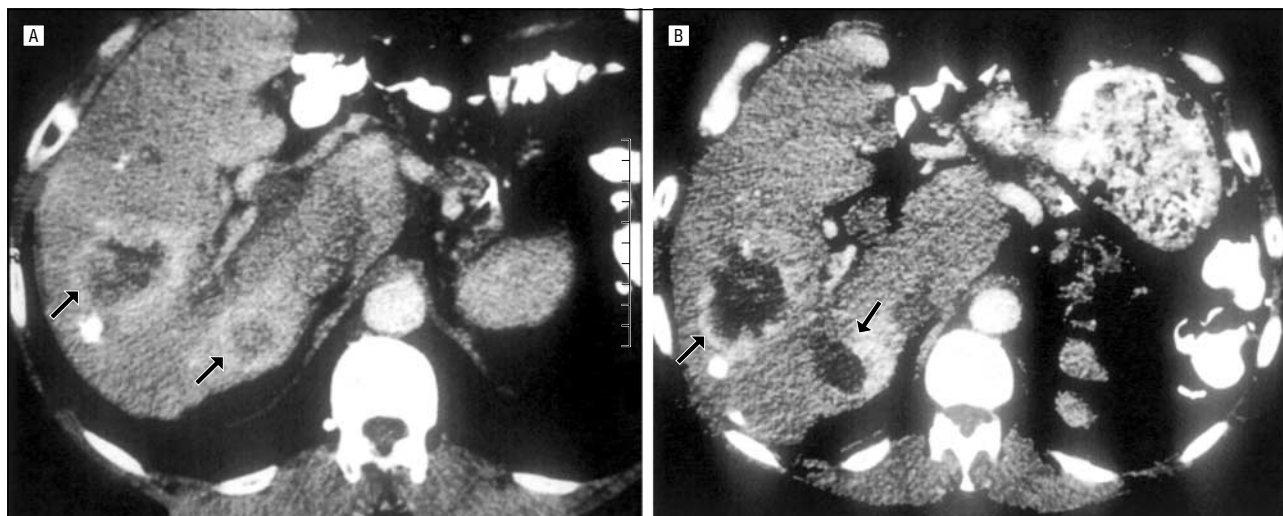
Computed tomographic scan demonstrating persistent tumor following treatment. A, Before treatment for 2 metastatic tumors from a neuroendocrine primary tumor, the uptake of contrast within and surrounding the tumors (arrows) indicates active tumor vascularization. The size of the larger tumor was 7 cm; the smaller, 5 cm. B, Following treatment by percutaneous cryosurgery, the persistence of contrast within and at the periphery of the tumors (arrows) indicates active tumor and unsuccessful treatment.
